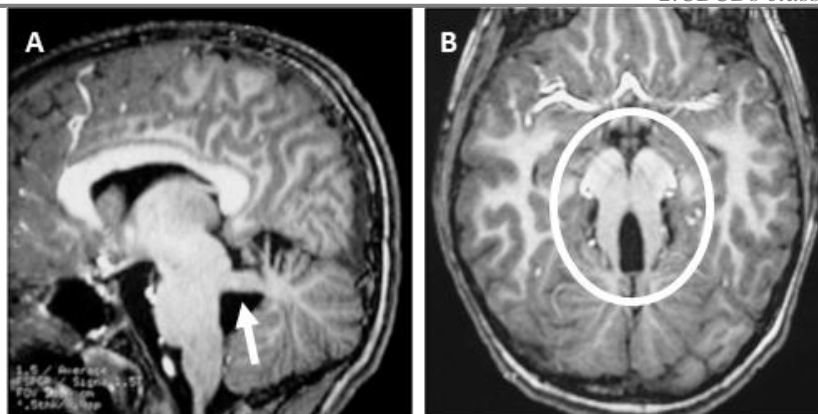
Midsagittal MR image showing elongated, thickened, and horizontally oriented superior cerebellar peduncles (A); axial MR image showing Deep interpeduncular fossa “Molar tooth sign” (B).
